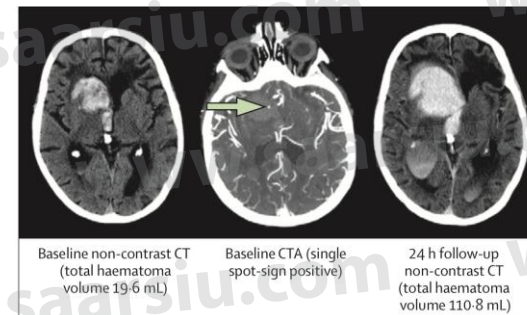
A sign with spot-like appearance on CTA in a patient with intracerebral haemorrhage
